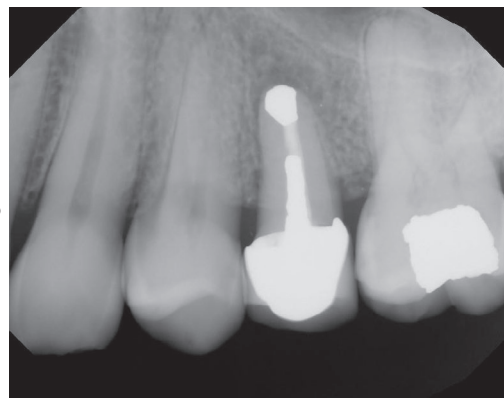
Periapical radiograph 8 weeks postoperatively
